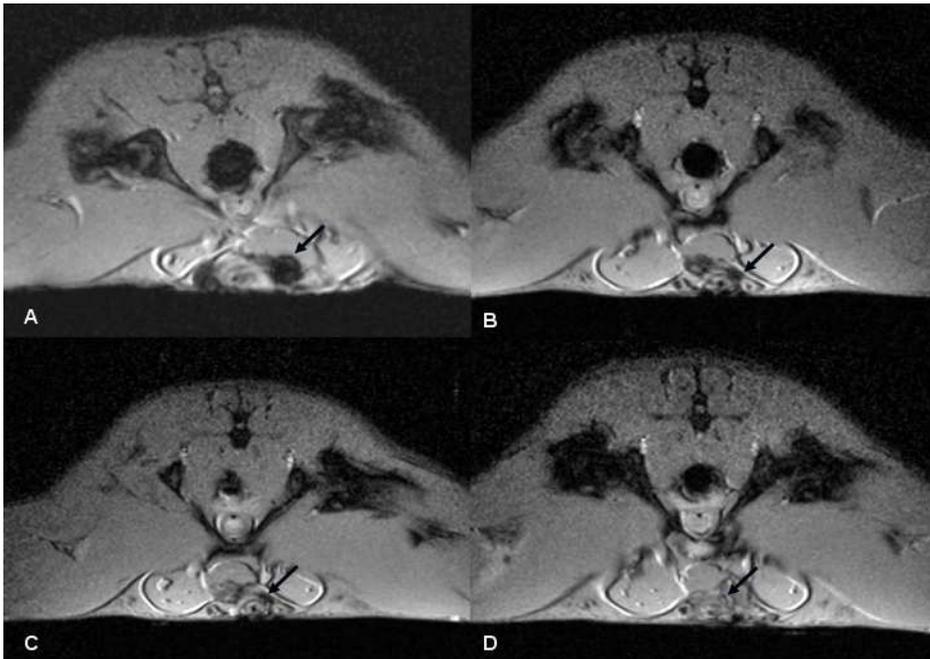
In vivo MRI with MSCs injection after transaction of bilateral cavernous nerves.
